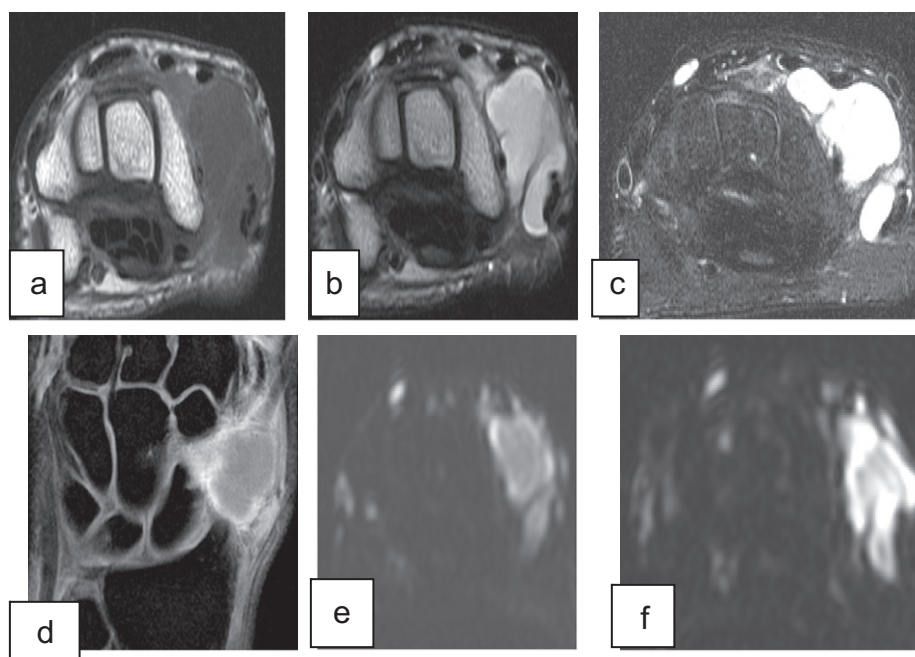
Ganglion cyst on the lateral aspect of the wrist appears of low signal in axial T1WIs(a), high signal in axial T2WIs and fat suppression sequence (b,c), with no appreciable contrast enhancement in fat suppression T1WIs(d). No restriction in DWI(e,f) and ADC. ADC Value 2.8 ± 0.23 .
